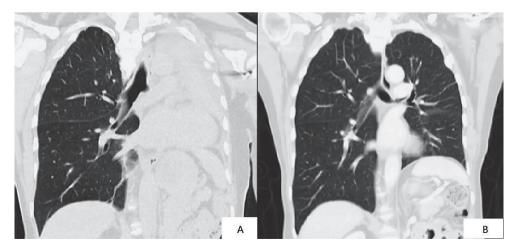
Pre- and post-operation chest CT scans (A). Left main bronchus occlusion and total collapse of the left lung in January 2019. (B). Slight focal narrowing of the left main bronchus with full expansion of the left lung in November 2019.
